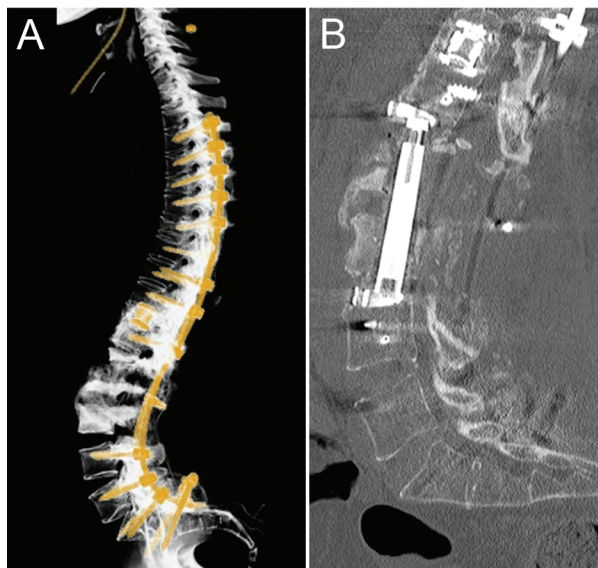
Images obtained in the patient after the 3-stage procedure. A: Sagittal 3D reconstructed CT scan of the spine with hardware windowing after posterolateral spinal fusion from T-3 to the ileum. B: Sagittal thoracolumbar CT scan of the final construct after retroperitoneal L1–3 corpectomies and anterior column reconstruction with interbody expandable cage, anterolateral plate, and vertebral body screw instrumentation.
